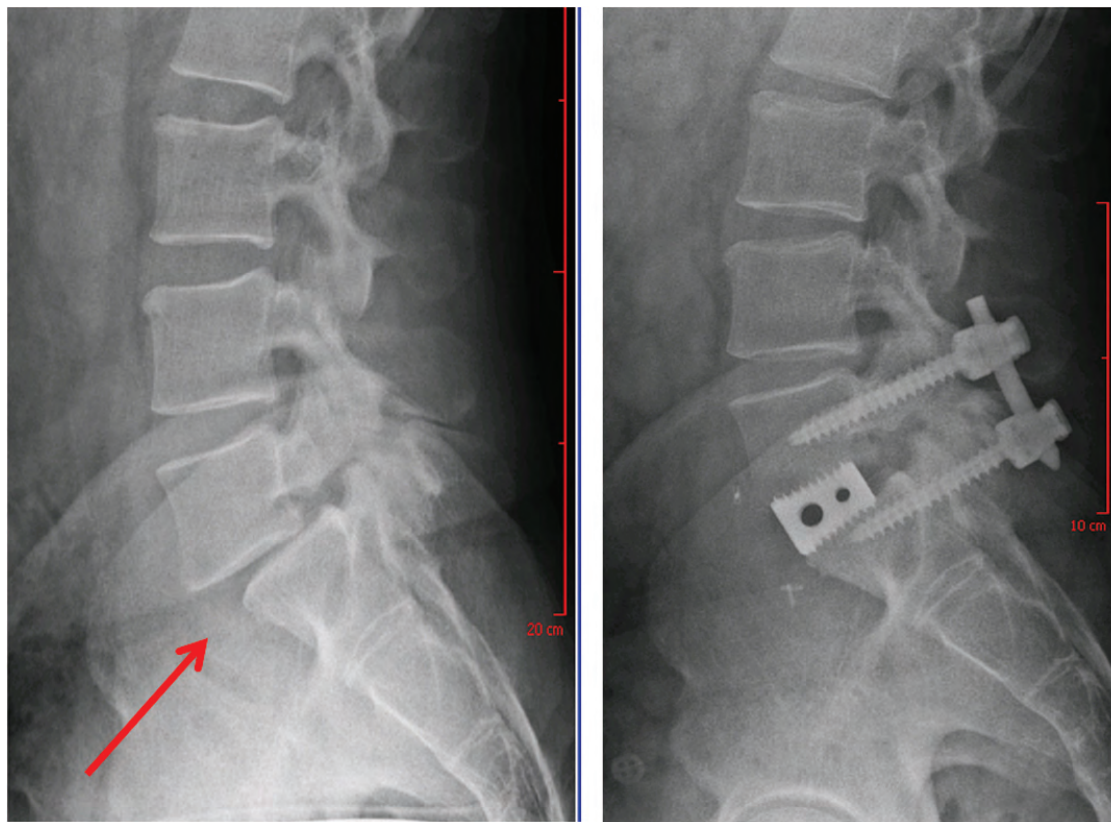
X-rays of a patient before and after minimally invasive correction of spondylolisthesis of the lumbar spine. Progressive disc collapse and slippage of the bone (red arrow) has been corrected using minimally invasive techniques. Using robot-guidance, the screws were placed in the back through an incision one inch in length.
